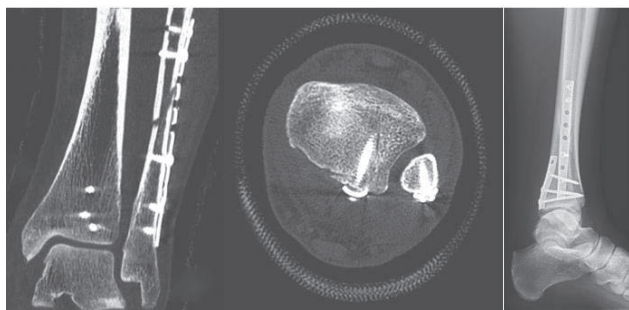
Postoperative X-rays after posterior fixation of both the fibula and posterior fragment.
